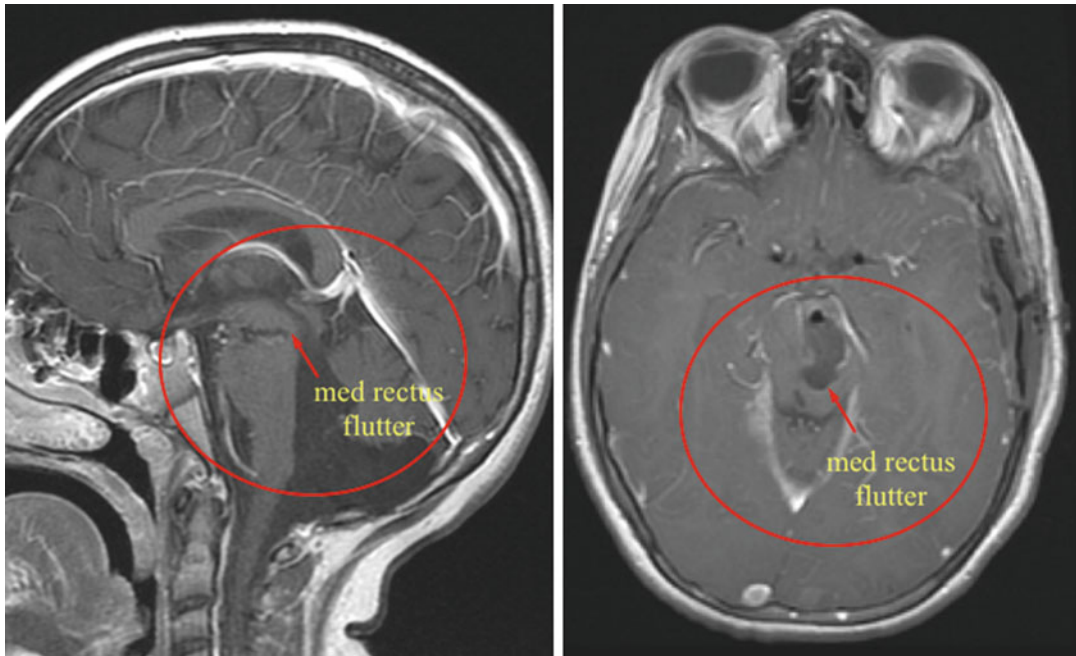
Postoperative MRI, sagittal T1 (*left*), and axial T1 (*right*) show gross total resection of tumor and the deepest extent of the resection front adjacent to the left oculomotor
